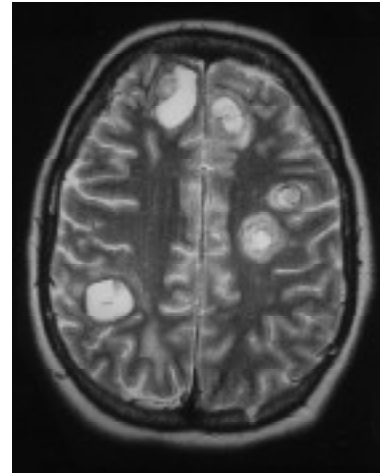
Axial fast spin echo T2-weighted MR image of a patient with haemorrhagic metastases of the brain due to melanoma shows multiple lesions which have mixed methaemoglobin and haemosiderin blood products. These may mimic multifocal cavernous malformations.
